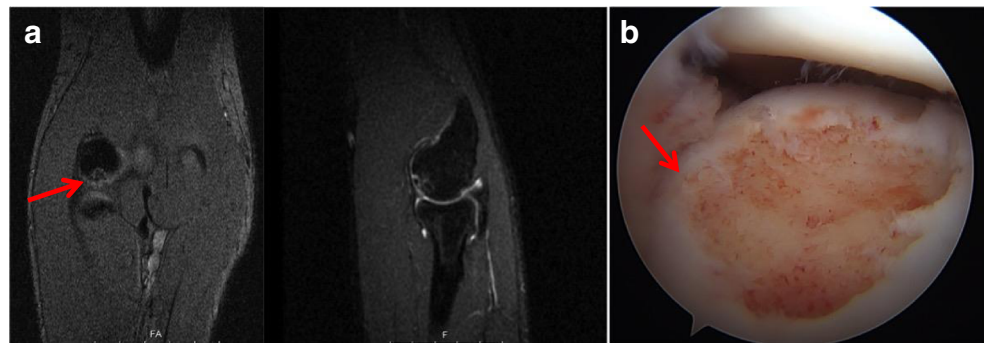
OCD lesion with an intact lateral buttress (arrow) seen on MRI (a) and intraoperatively during arthroscopy with the patient in supine position (b)
